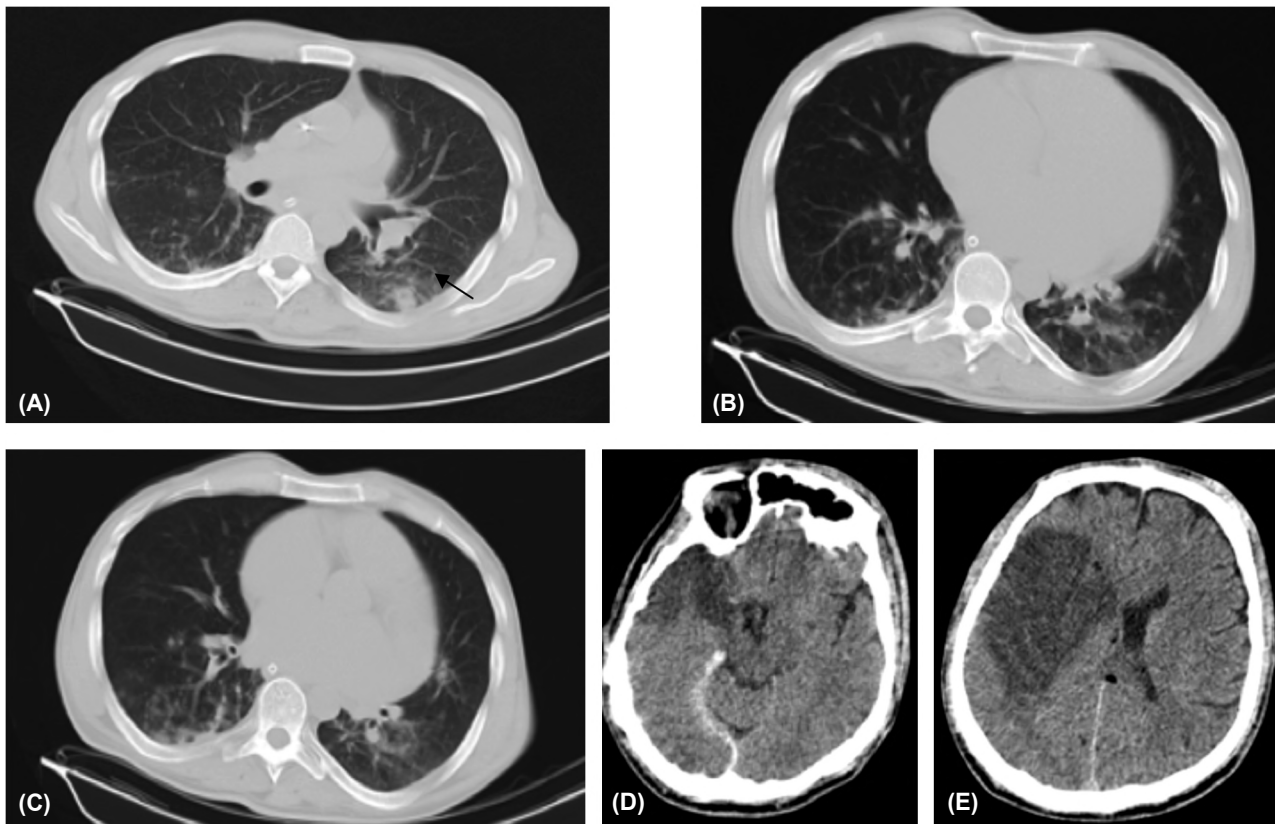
33 years old male patient with dyspnea followed by left sided weakness and disturbed conscious level after 3 days (A,B,C) Axial CT chest lung window, CT severity score 8, with atoll sign, arrow in (A), crazy paving pattern in (B) and tree in bud pattern in (C). (D,E) Axial CT cuts of the brain showing right sided tentorial leaflet subdural hemorrhage in (D) and right fronto parietal acute ischemic infarction along right MCA territory (E).
